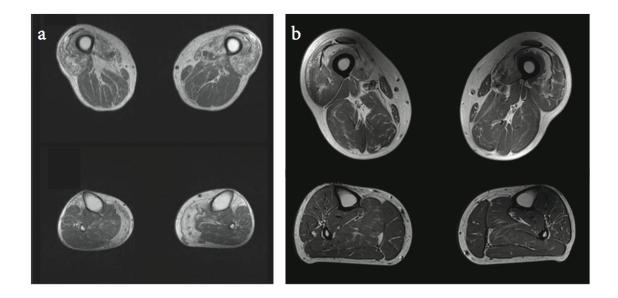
MRI images of case 10 and corresponding images from Reilich *et al* study from patient with the same variation Gly154Ser in CRYAB gene a) T1 weighted MRI of thigh and calf from patient with Gly154Ser in CRYAB from (Reilich et al., 2010). b) T1 weighted MRI of thigh and calf from Case 10 who also carries the Gly154Ser
